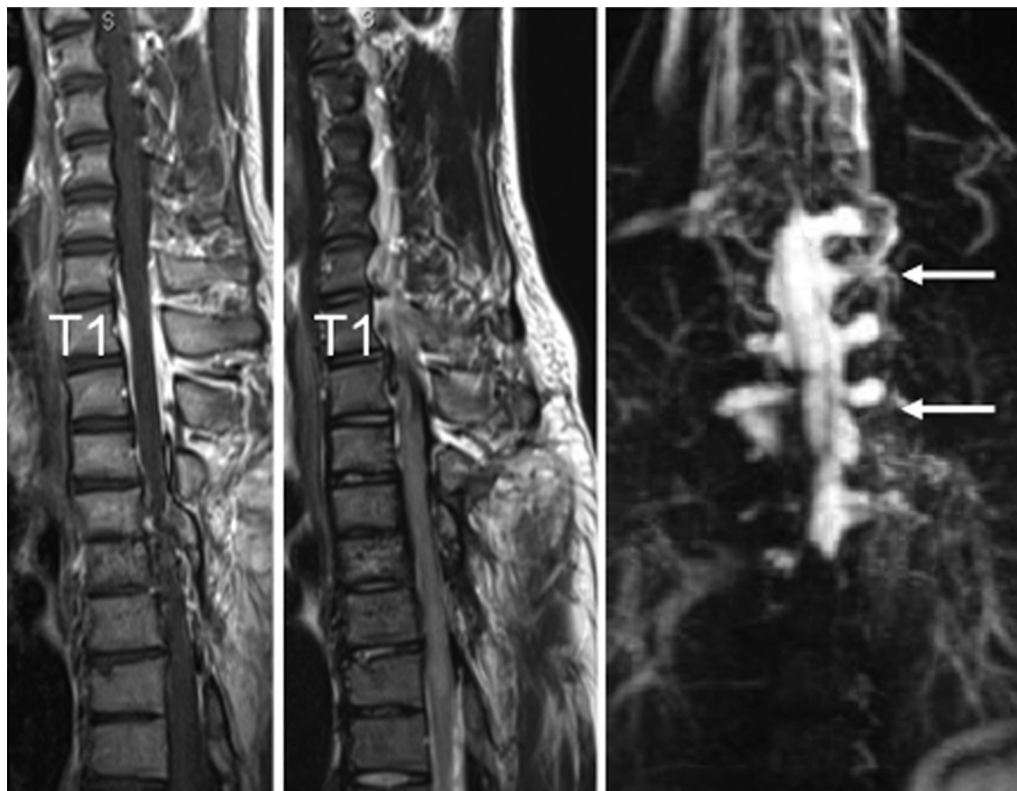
Magnetic resonance image of the patient's cervical and thoracic spine on admission. (Left) T1-weighted gadolinium enhanced sagittal image showing enlargement of the epidural venous plexus from C7 to T3. (Middle) T2-weighted sagittal image showing no abnormal flow void along the spinal cord surface. There was no T2 high-intensity area in the spinal cord. (Right) Magnetic resonance angiogram demonstrating ectasia of the epidural venous plexus (arrows). "T1" indicates (Left and Middle) the vertebral level.
